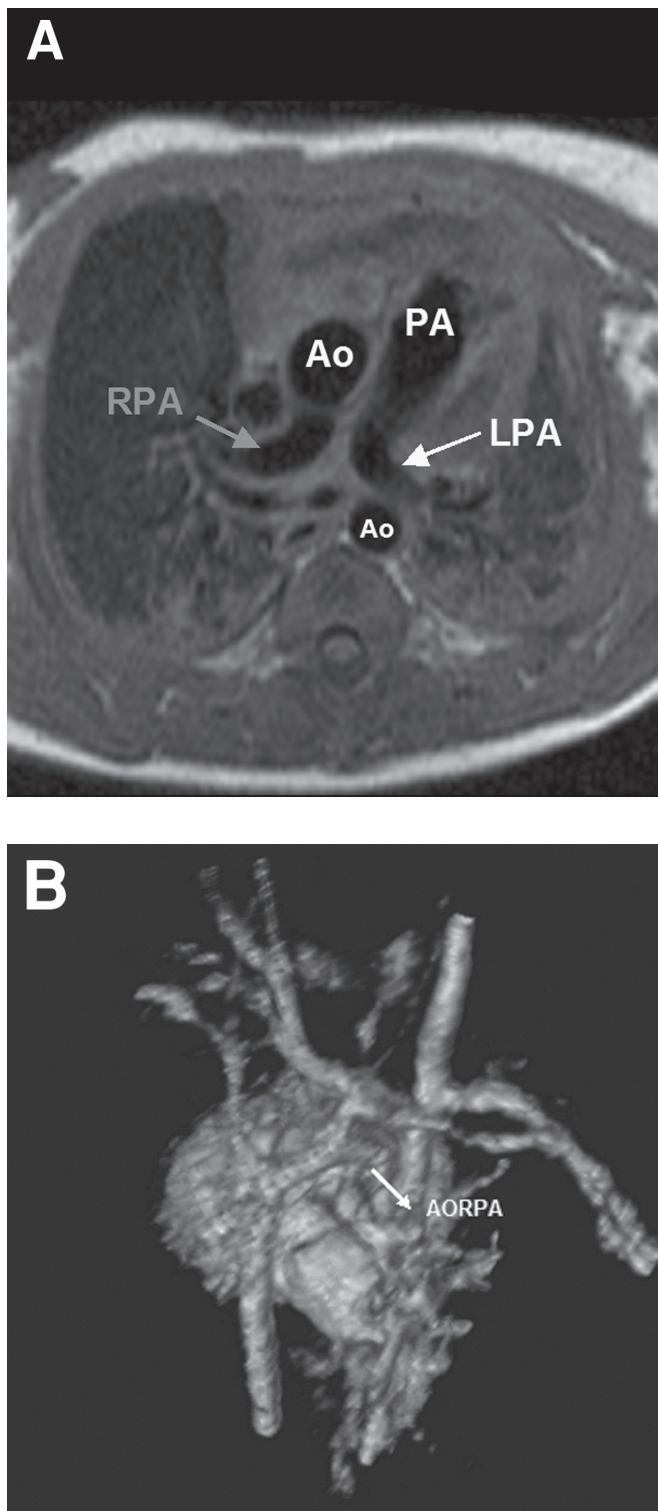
A, cardiac magnetic resonance imaging (MRI) of a 5-week-old boy with anomalous origin of right pulmonary artery (AORPA) prior to complete repair without bypass. B, 3D cardiac MRI reconstruction (right posterior view) of the same patient depicts the AORPA. Ao indicates aorta; PA, pulmonary artery; LPA, left pulmonary artery; RPA, right pulmonary artery.
